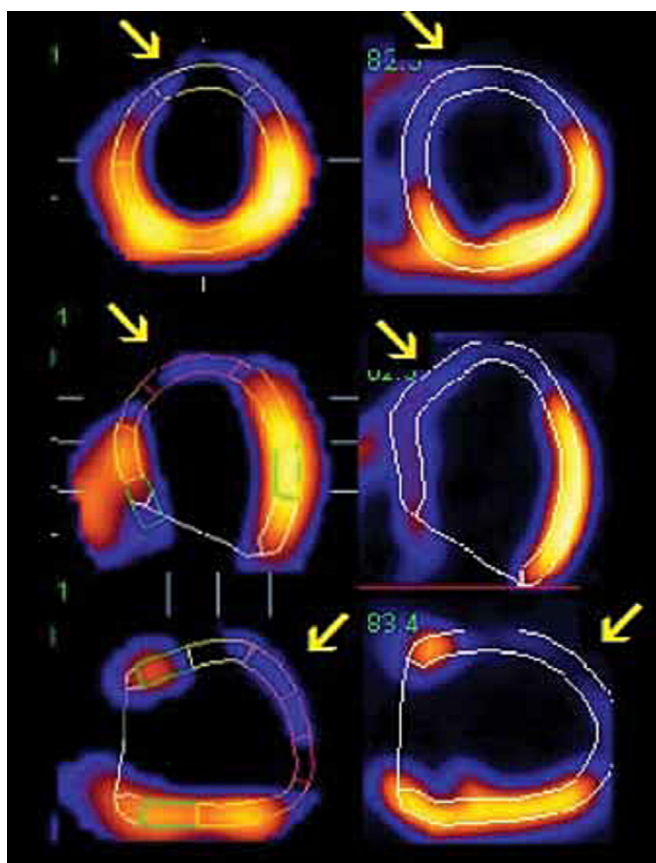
Image shows the equivalence of $^{99\text{m}}\text{Tc}$ -MIBI perfusion (left) and ^{18}F FDG uptake (right) and where arrows indicate extensive perfusion defect (Kobylecka et al., 2012).
